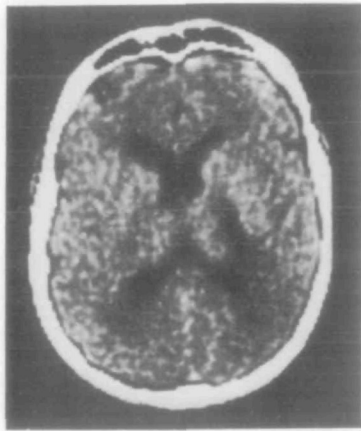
Case 2.* CT scan, showing area of reduced density in posterior limb of right internal capsule.
